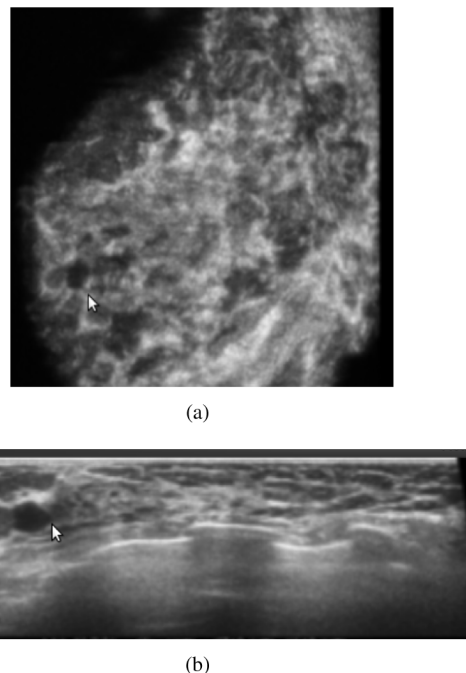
Benign lesion in ABUS (indicated by the arrow). Two slices through the lesion are shown, a coronal slice (a) which is obtained from transforming the original stack of transversal images and a transversal slice (b) which is acquired by the probe at a particular location. The latter view is similar to a regular handheld ultrasound image.
